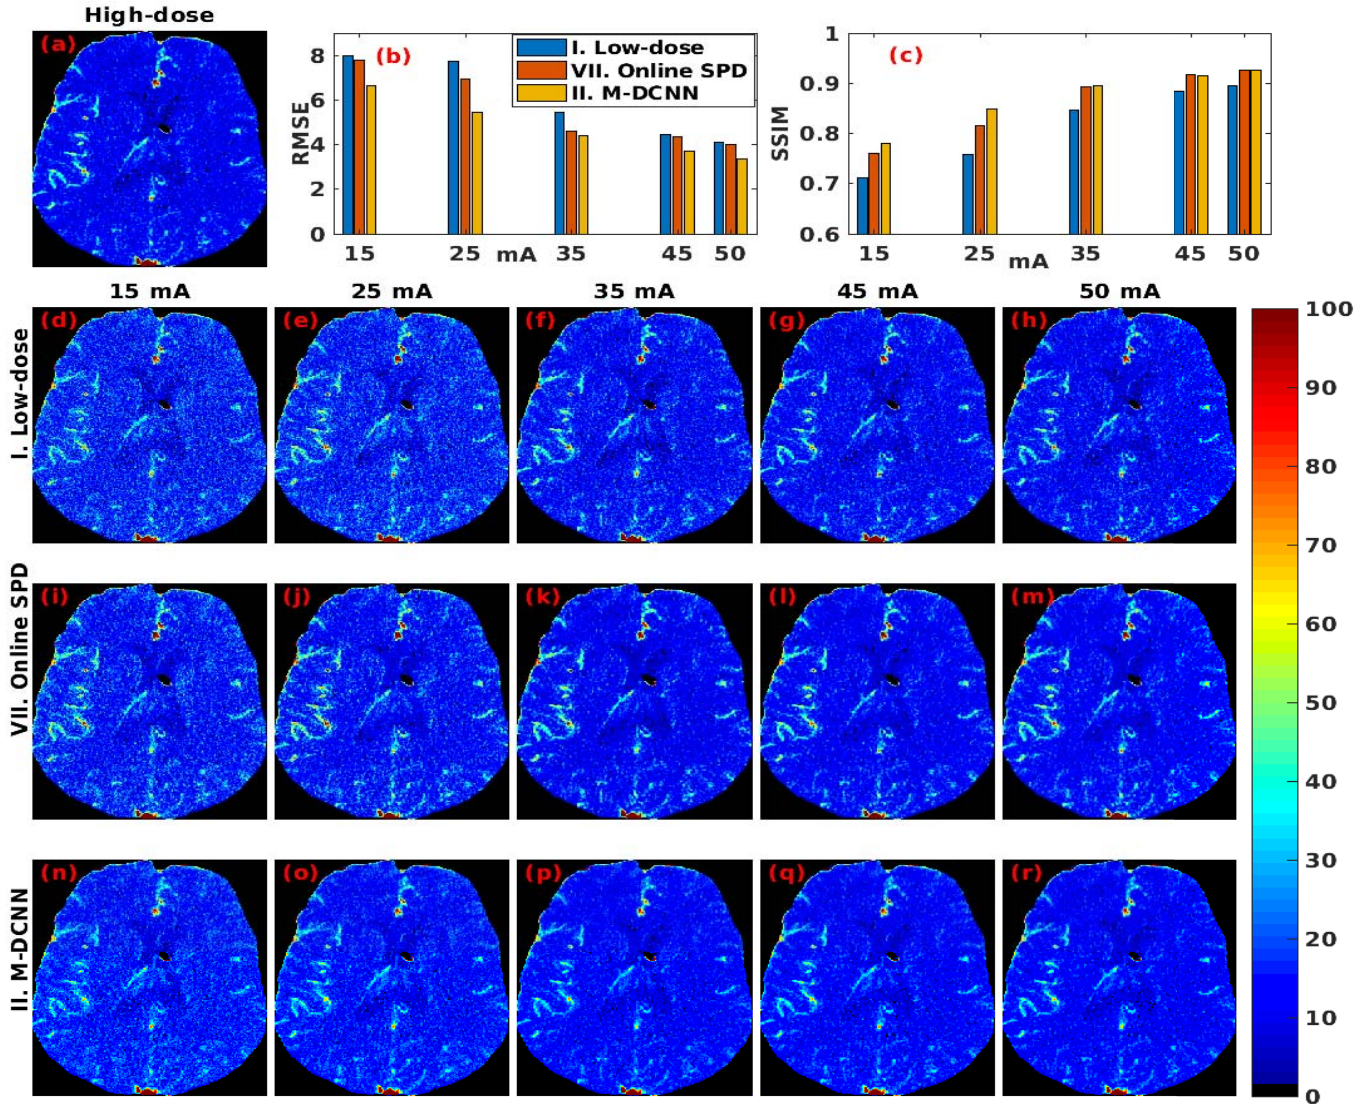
Results pertaining to the middle slice of *in-vivo* CT perfusion data of a 35 years old female with vasospasm in aneurysmal SAH, which caused LMCA perfusion deficit. The reference CBF map corresponding to the high-dose CT perfusion data acquired at 190 mA is given in (a). The low-dose CBF maps (obtained using method-I described in Section II-G) computed using the analogous perfusion data corresponding to the X-ray tube current of (d) 15 mA, (e) 25 mA, (f) 35 mA, (g) 45 mA, and (h) 50 mA. Corresponding denoised maps using the online SPD (method-VII in Section II-G) are given in (i)–(m). The proposed M-DCNN (method-II in Section II-G) results are given in (n)–(r) correspondingly. The figures of merit, RMSE, and SSIM computed for last three rows of CBF maps are shown in (b) and (c), respectively.
